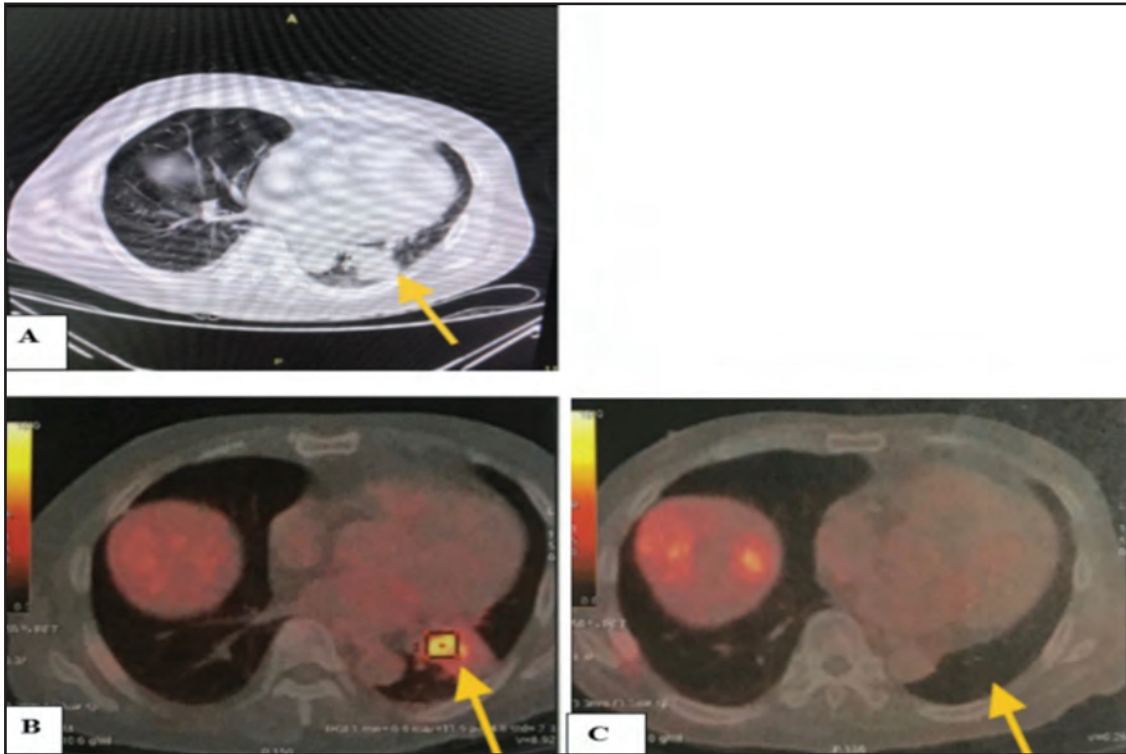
Ga-68 DOATATE PET/CT scan showing (A) irregular left lower lobe lung mass before lobectomy (B) with the SUV max of 11.9 (C) has resolved after the surgery.
